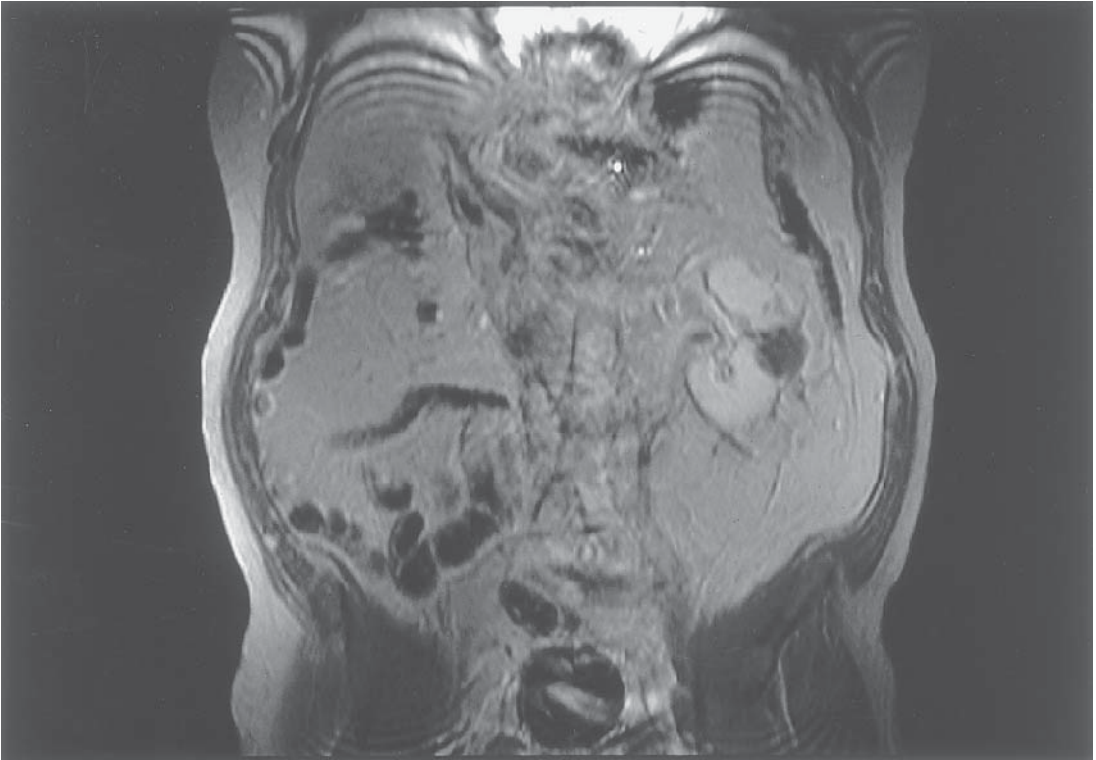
Postoperative MRI image showing the punched-out circular defect in the left kidney representing the cryoablated tumor.
